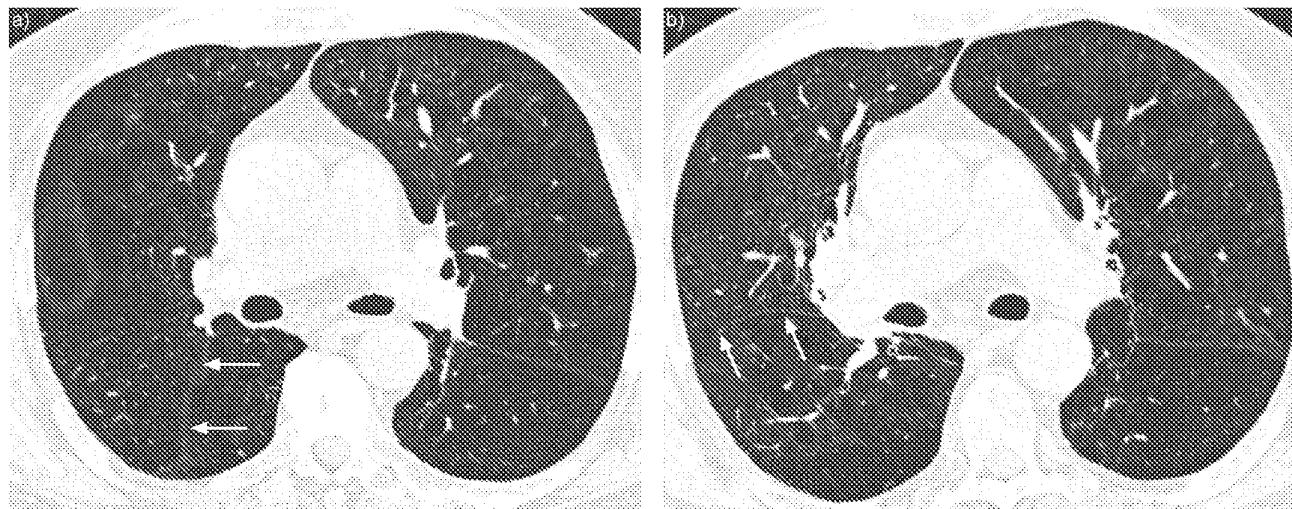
a) A computed tomography (CT) scan taken at baseline before the IBV® Valve (Spiration Inc., Redmond, WA, USA) treatment; and b) a matched CT scan acquired 6 months following treatment. Notice the shift in the major fissure (white arrow) in the right lung which was associated with a 1,555 mL decrease in upper lobe volume and a 1,200 mL increase in nonupper lobe volume.
